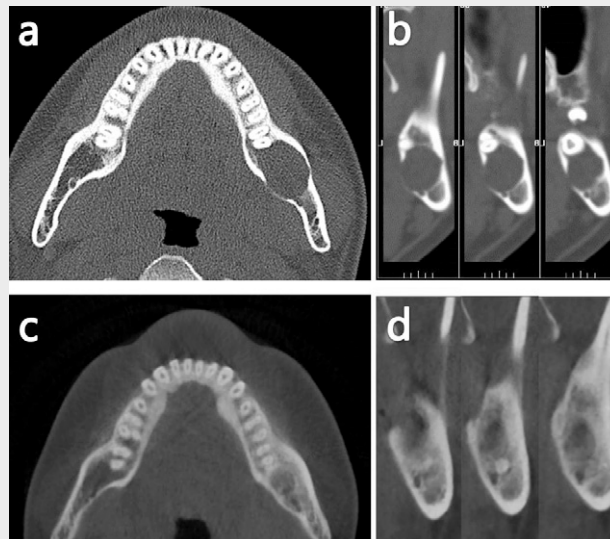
Computed tomography of case 3.
